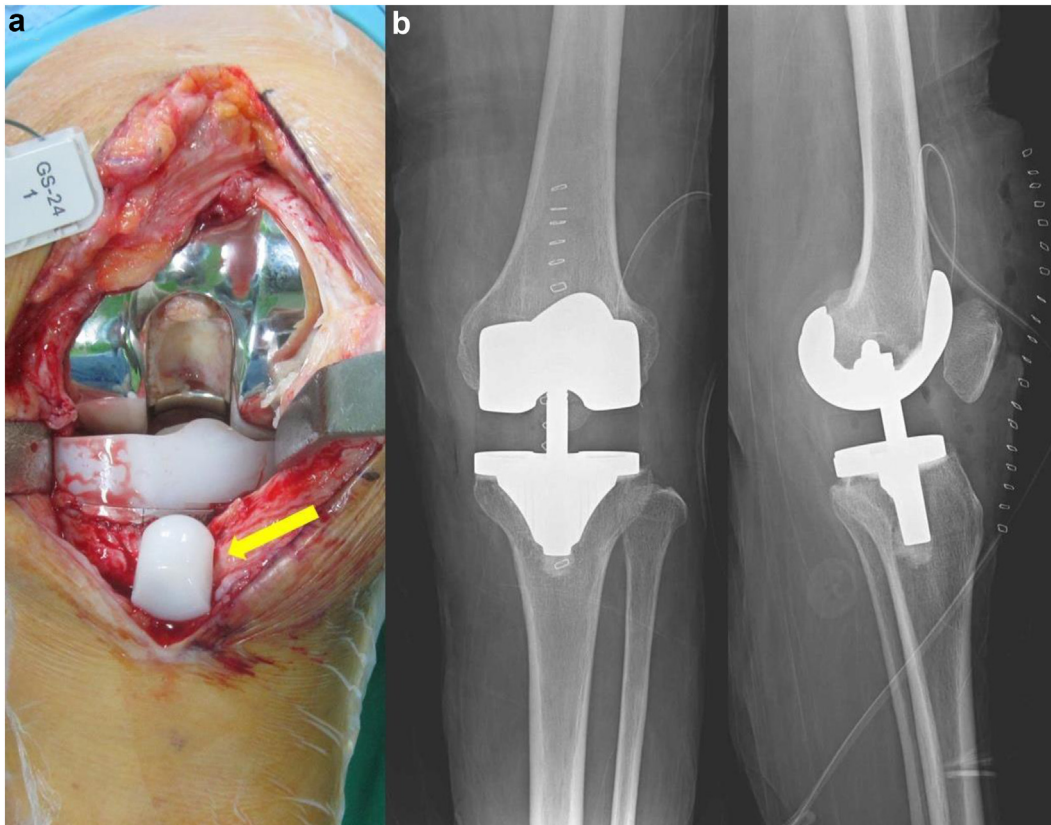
(a) Intraoperative photographic findings of patient 1. A broken tibial post (yellow arrow) was found in the intercondylar notch. (b) Postoperative radiographs showing exchange for a total stabilizer (TS) tibial insert with an increased thickness (21 mm) after a tibial post refracture.
